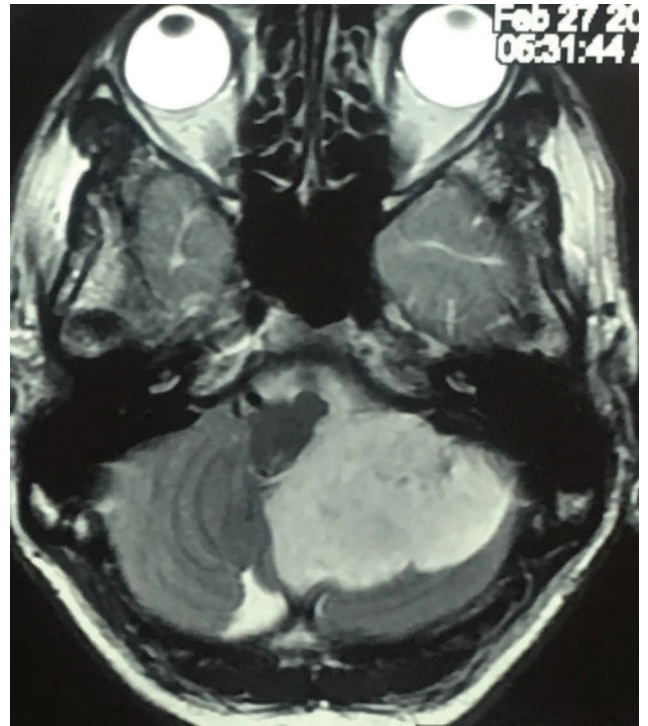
MRI of left cerebellopontine angle epidermoid tumor.
